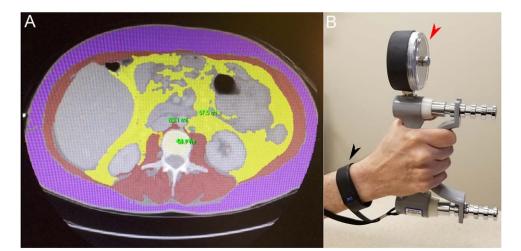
Measuring sarcopenia, physical activity, and frailty. (A) A computed tomography cross section at vertebral level L3 with muscle highlighted in red, used for calculation of the SMI as square centimeters (cm²) of muscle area divided by the square of patient height (m²).⁴ Gender-specific SMI cutoffs, 50 cm²/m² in men and 39 cm²/m² in women, are proposed to standardize sarcopenia measurement in liver transplant candidates.⁶ (B) Black arrowhead: a wearable personal activity monitor. Web-based transmission delivers step count, heart rate, calories expended, and activity intensity to a user's smartphone and their electronic medical record.⁸ Red arrowhead: a dynamometer for measuring grip strength, a component of the LFI.⁹
